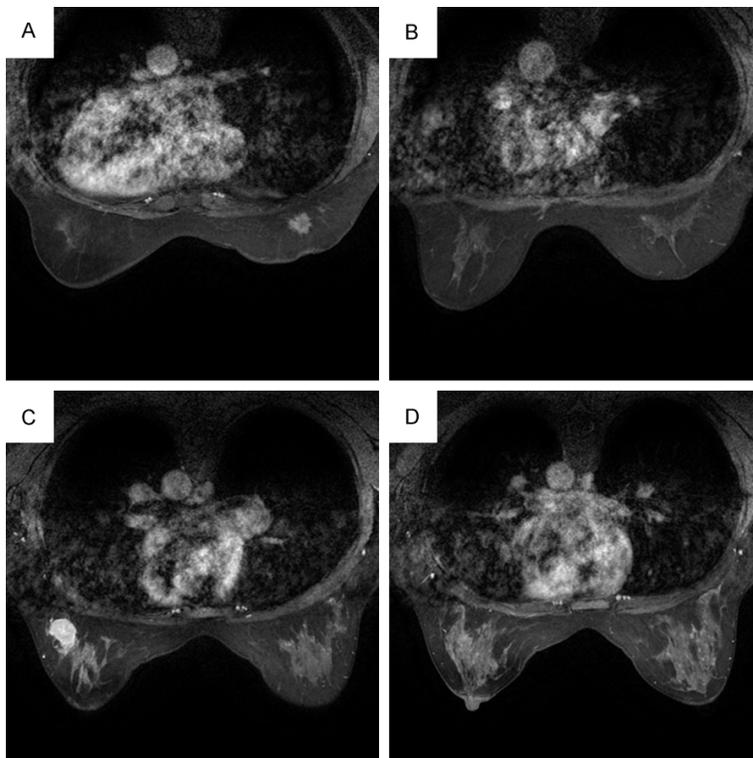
Pretreatment breast MRI in a 59-year-old female with triple-negative breast cancer (A, B). The fat-saturated contrast-enhanced T1-weighted images in the early phase show an irregular tumor in the lower quadrant of the right breast (A) and mild background parenchymal enhancement in the contralateral breast (B). This patient underwent adjuvant chemotherapy after surgery and experienced local-regional recurrences and lung metastases after a follow-up of 37 months. Pretreatment breast MRI in a 43-year-old female with triple-negative breast cancer (C, D). The fat-suppressed contrast-enhanced T1-weighted images in the early phase show a lobulated tumor in the upper outer quadrant of the left breast (C) and moderate background parenchymal enhancement in the contralateral breast (D). This patient received chemotherapy after surgery, and no recurrence was detected in a recent follow-up.
